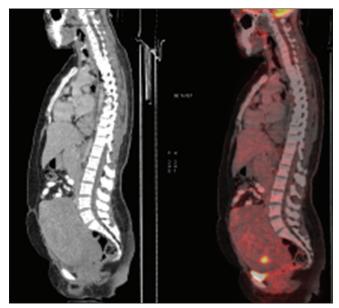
PET-CT saggital images show large pelvic mass, extending into abdominal region reaching till supra-umblical level
